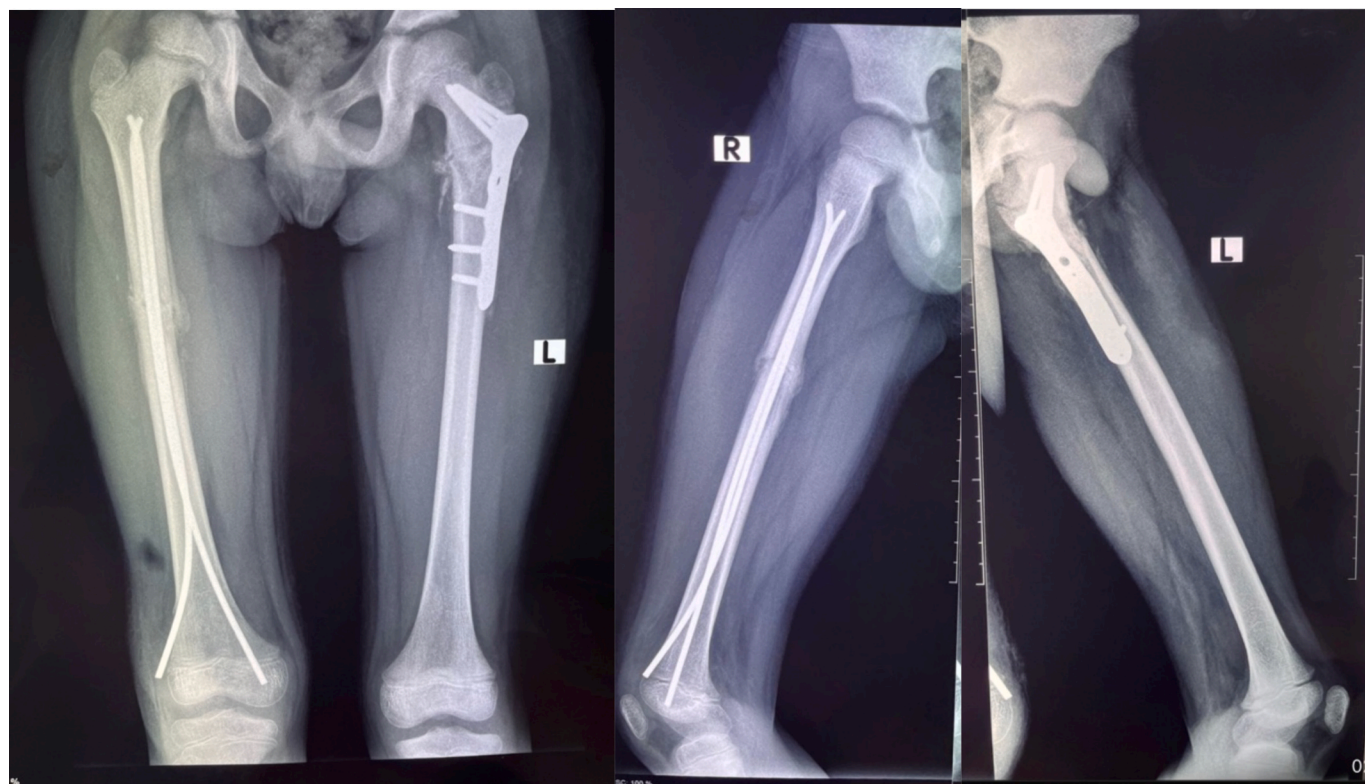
Anteroposterior radiographs at four weeks post operation, with healing fractures.
